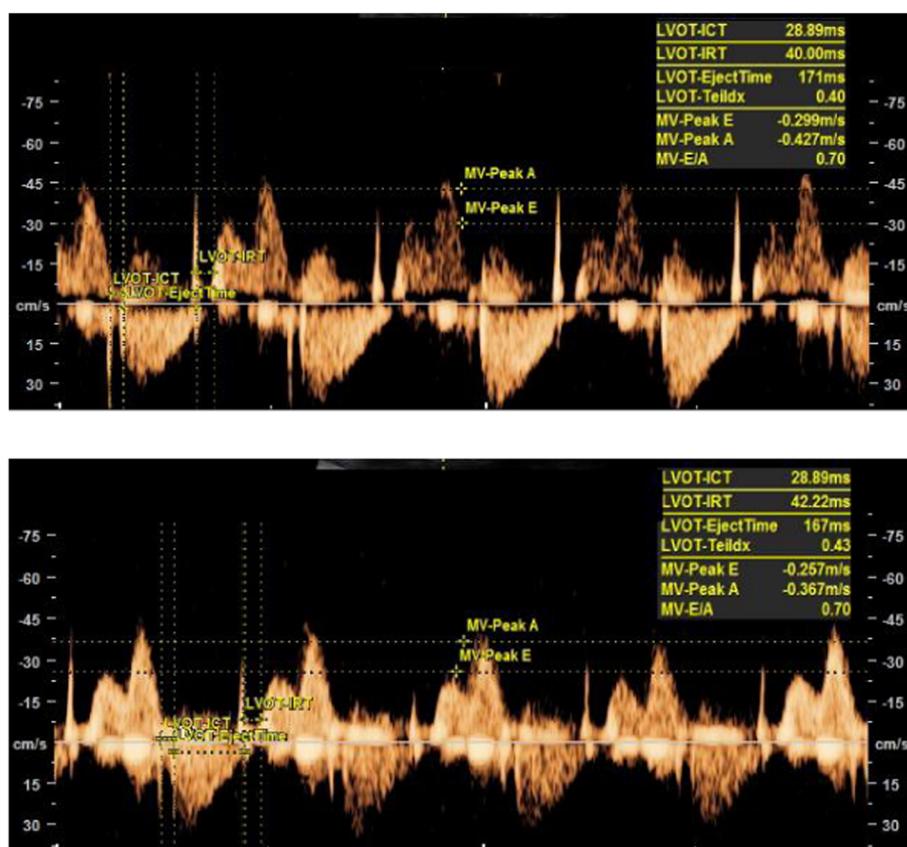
Normal myocardial performance index and E wave/A wave peak velocity ratio Doppler tracings at the mitral valve
